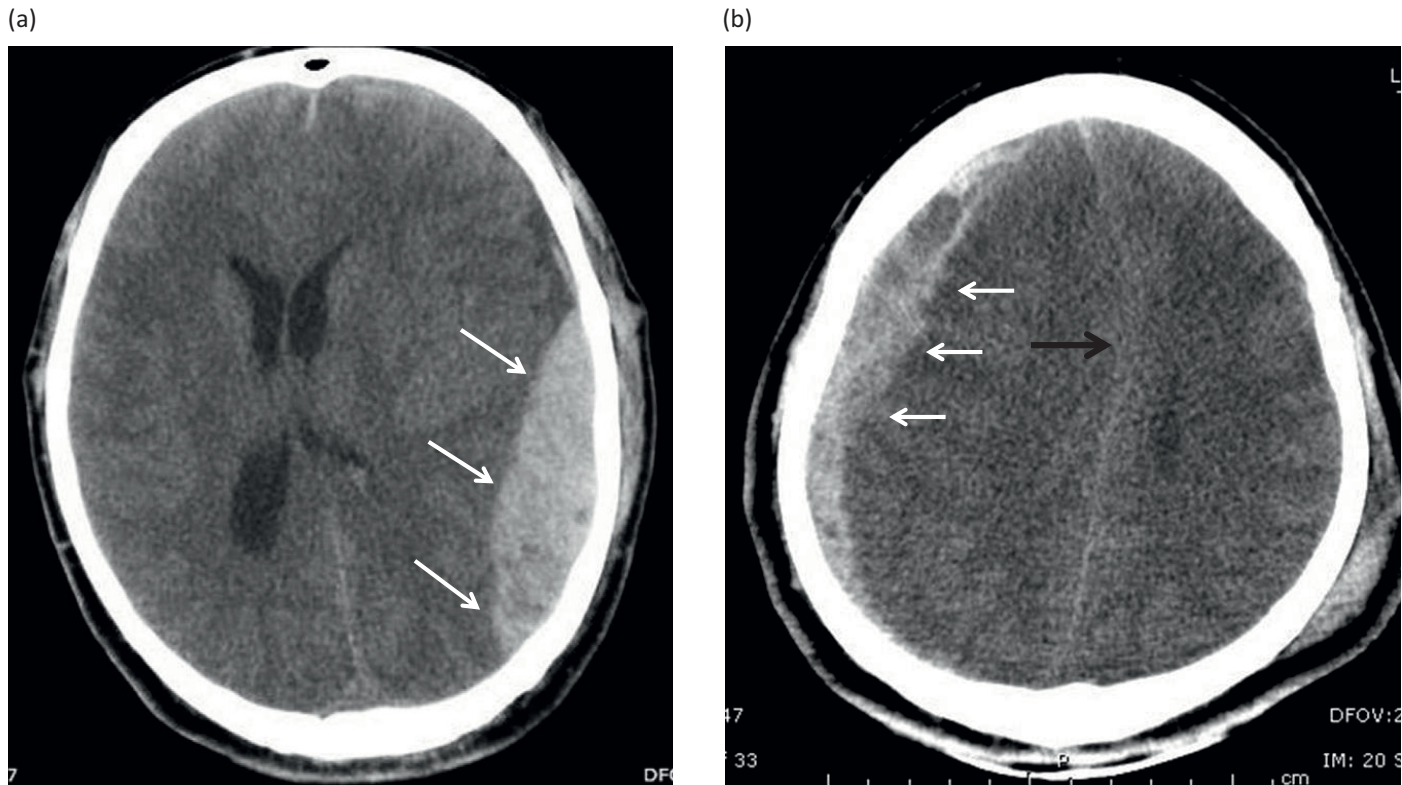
(a) CT scan appearance of an acute epidural hematoma. Note the lenticular (biconvex) shape of the hematoma (arrows). (b) CT scan appearance of an acute subdural hematoma. Note the crescent shape of the hematoma (white arrows). There is a significant midline shift (black arrow).
